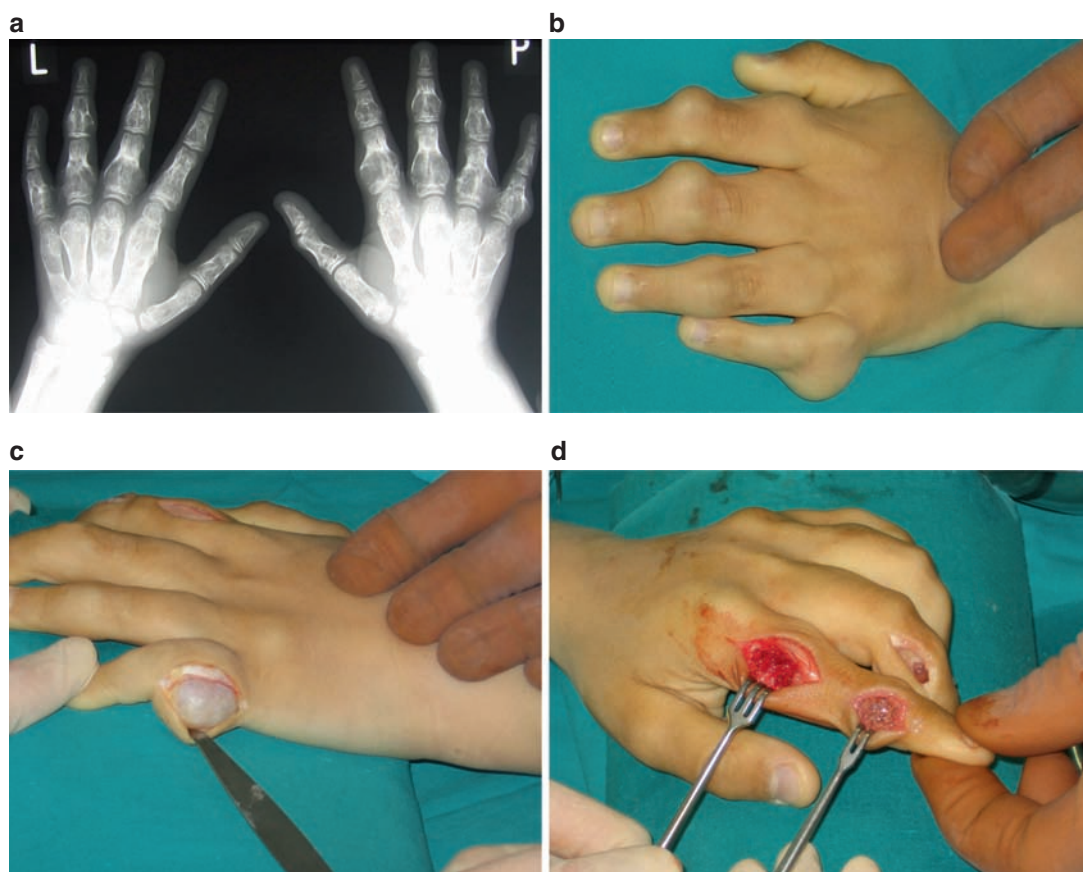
Multiple enchondroma. (a) X-ray of both hands. (b) Clinical presentation. (c) Intraoperative view. (d) Tumors curettaged and filled with autologous bone graft.
